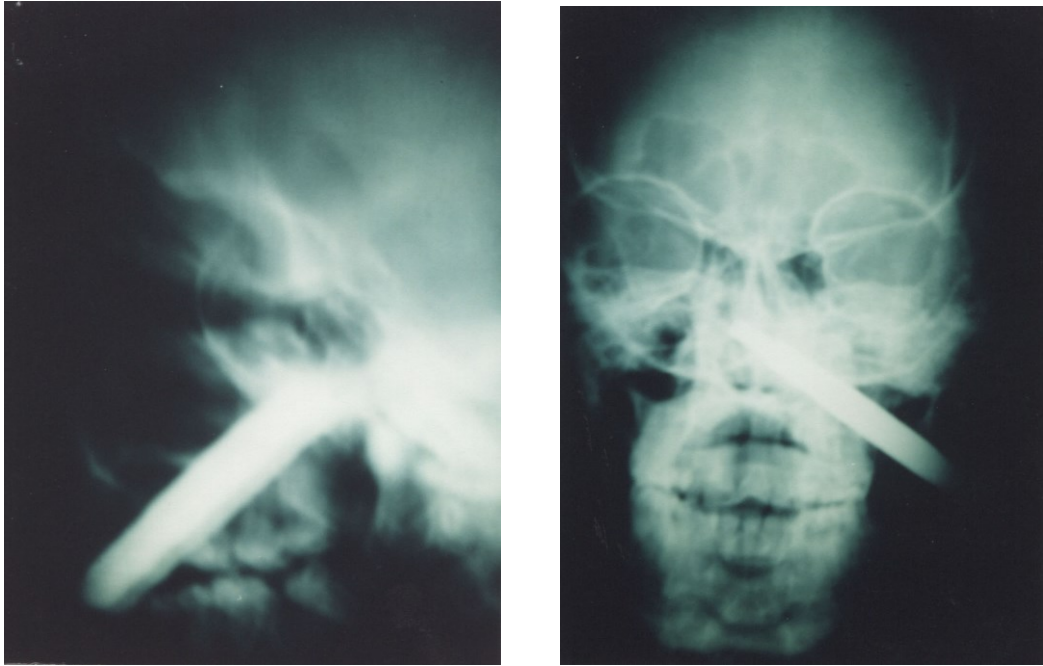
Lateral (left) and anteroposterior (right) radiographs of metallic foreign body lodged in mid face (case 3)
